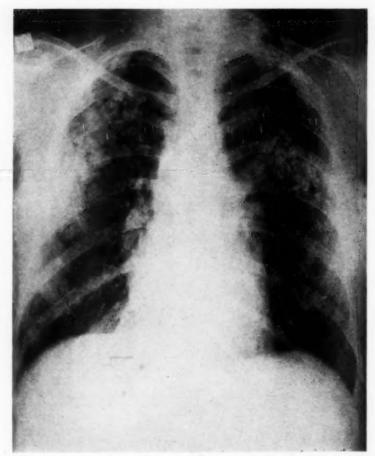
(Case 2.) Roentgenogram showing striking increase of calcium deposits in 1950.
